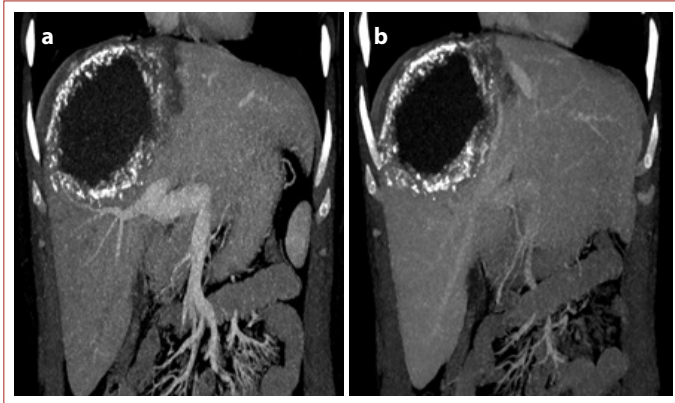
(a, b) Preoperative dynamic CT image of.
